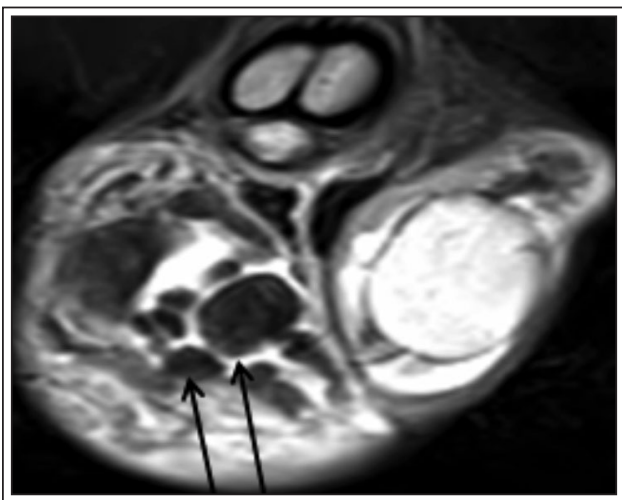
T1-weighted MR image. Contrast-enhancing nodules (arrows) found to be arising from the tunica vaginalis.
